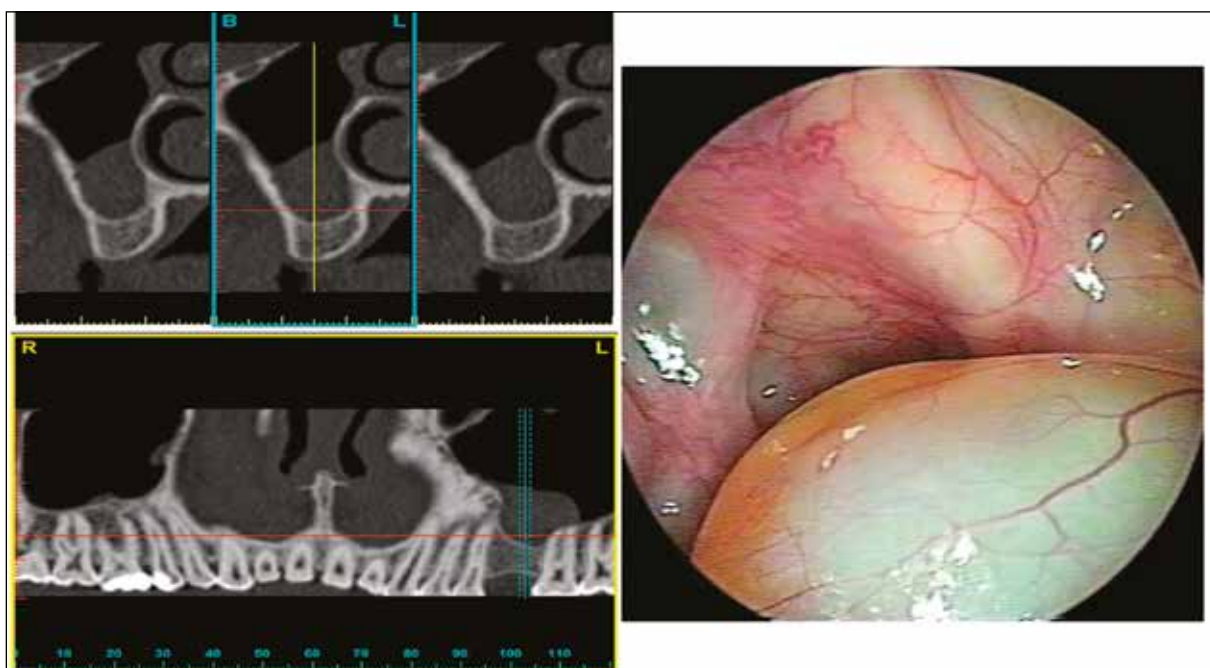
Fragment of computed tomography of the upper jaw of the 31-year-old male patient P., case record No.133. Diagnosis: edentulism of the upper jaw, Kennedy Class III. Endonasal visualization of cyst in the left maxillary sinus.
